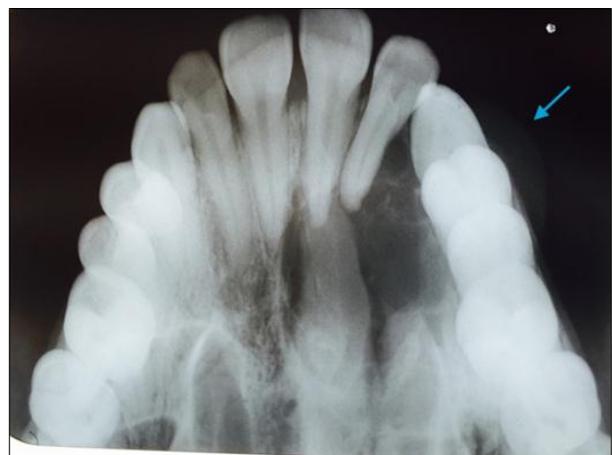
Maxillary cross sectional occlusal radiograph showing a multilocular lesion and its extent. Buccal cortical plate expansion (blue arrow) is seen.
